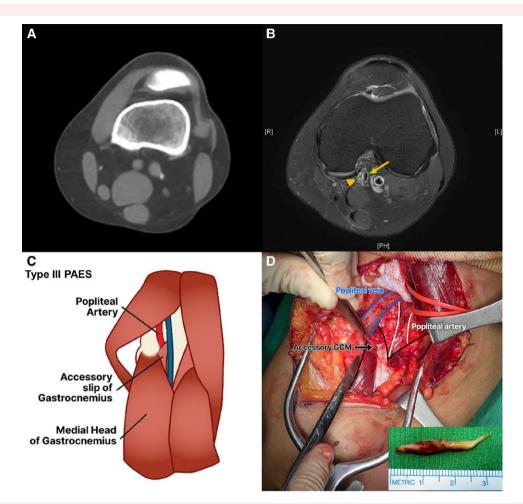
Key images of Case 1. The fibrotic band is unclear in the computed tomography section (A) but is clearly visible on the magnetic resonance imaging (green arrow) (B), which helps explain the anatomical abnormality (C) in PAES Type 3. The organized thrombus was removed by thrombectomy alone (D).
